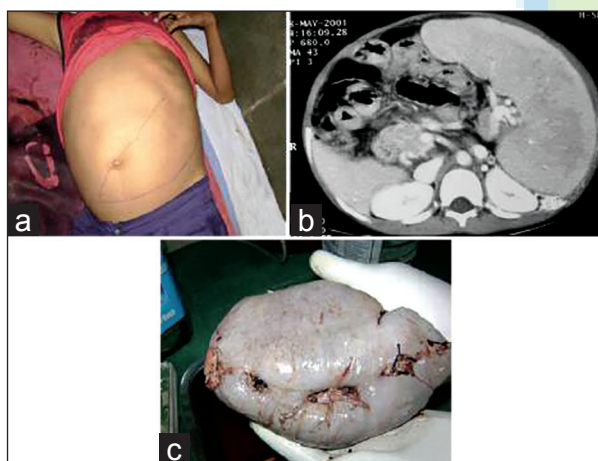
(a) Clinical splenic mass, (b) Contrast-enhanced computed tomography suggestive of splenomegaly, (c) Operative confirmation
